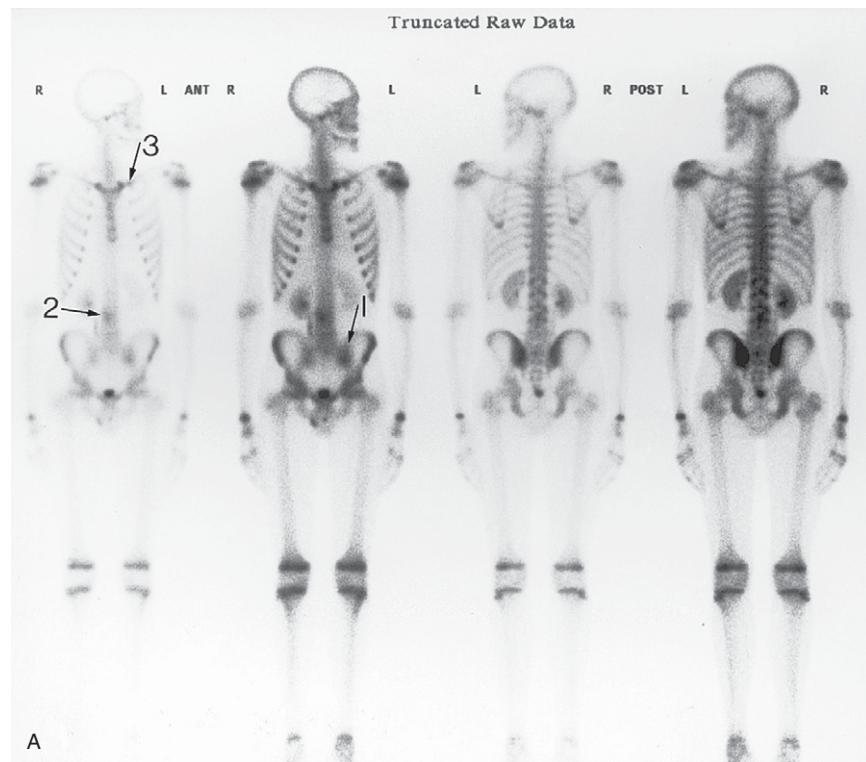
(A) The three phase bone scan with SPECT truncated raw data image shows 'activity in the left sacroiliac joint (arrow 1) and a slight increase in activity in the right side of the mid lumbar spine in the region of L3/L4 (arrow 2). Relatively increased tracer uptake in both shoulders is symmetrical and almost certainly represents activity in incompletely fused epiphyses. Increased tracer uptake is noted in the medial aspect of the left clavicle' (arrow 3). The 'hot spot' (arrow 2) at the L3–4 level is where surgery was later performed.
